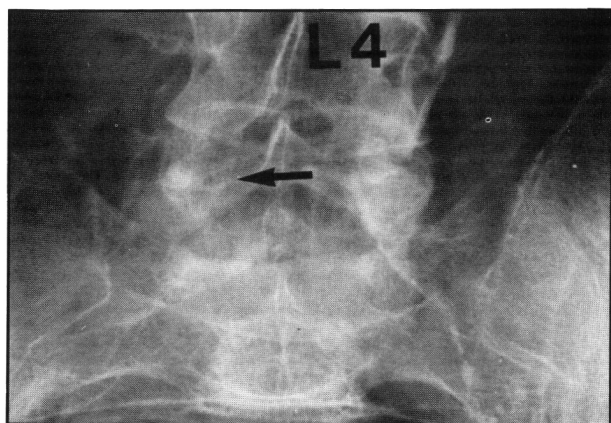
Plain x-ray of lumbosacral spine in anteroposterior view. Note the pedicle erosion of right L5 (arrow).
